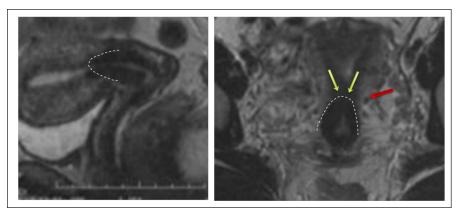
Normal cervical anatomy on T2w FSE MRI. Cranial border towards the uterine body is conical in shape (white dotted line and green arrows) and located around the level of the entry of uterine arteries (red arrow). Laterally, the cervix borders to parametria and caudally to vagina.
